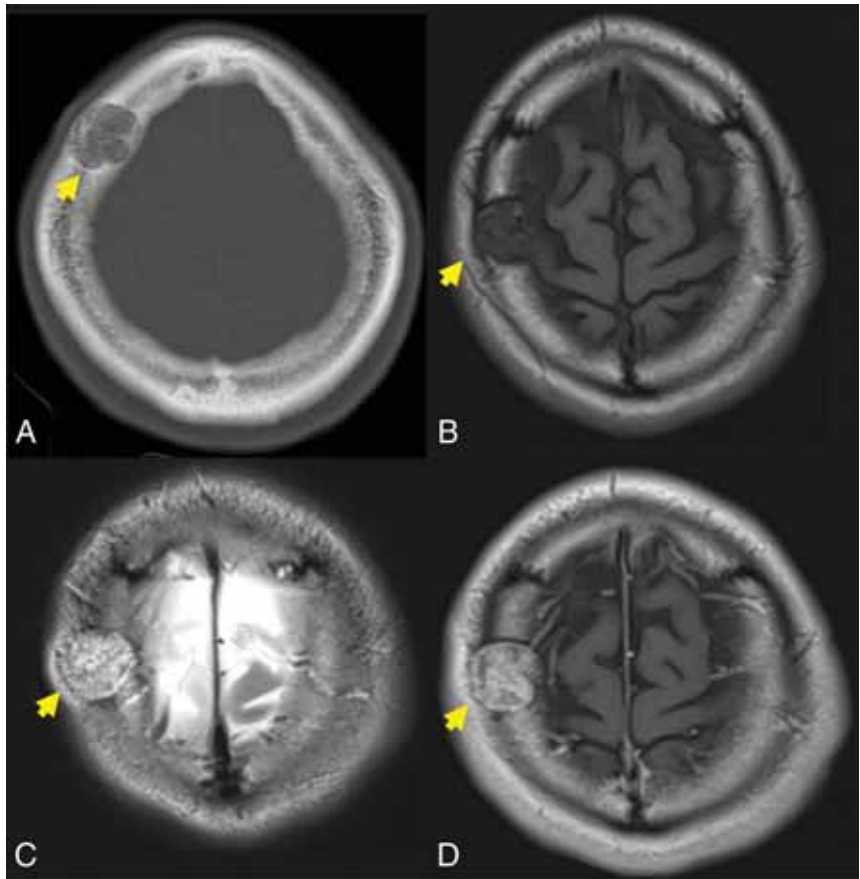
A 39-year-old man with a slowly growing calvarial mass. Axial CT (A) demonstrates a lucent right frontal bone lesion centered in the diploic space with a honeycomb pattern of internal calcification (arrow). Note a minimal overlying scalp deformity; the patient was able to palpate this slowly growing lesion. The lesion (arrow in B–D) demonstrates intermediate signal on T1WI (B), marked hyperintensity on T2WI (C), and prominent contrast enhancement, T1WI C+ (D). Note the internal foci of low signal most prominent on the T2-weighted examination (C) corresponding to the internal bone spicules evident on the CT. The diagnosis of IOVM was made on the basis of the characteristic imaging appearance. C+ indicates with contrast.
